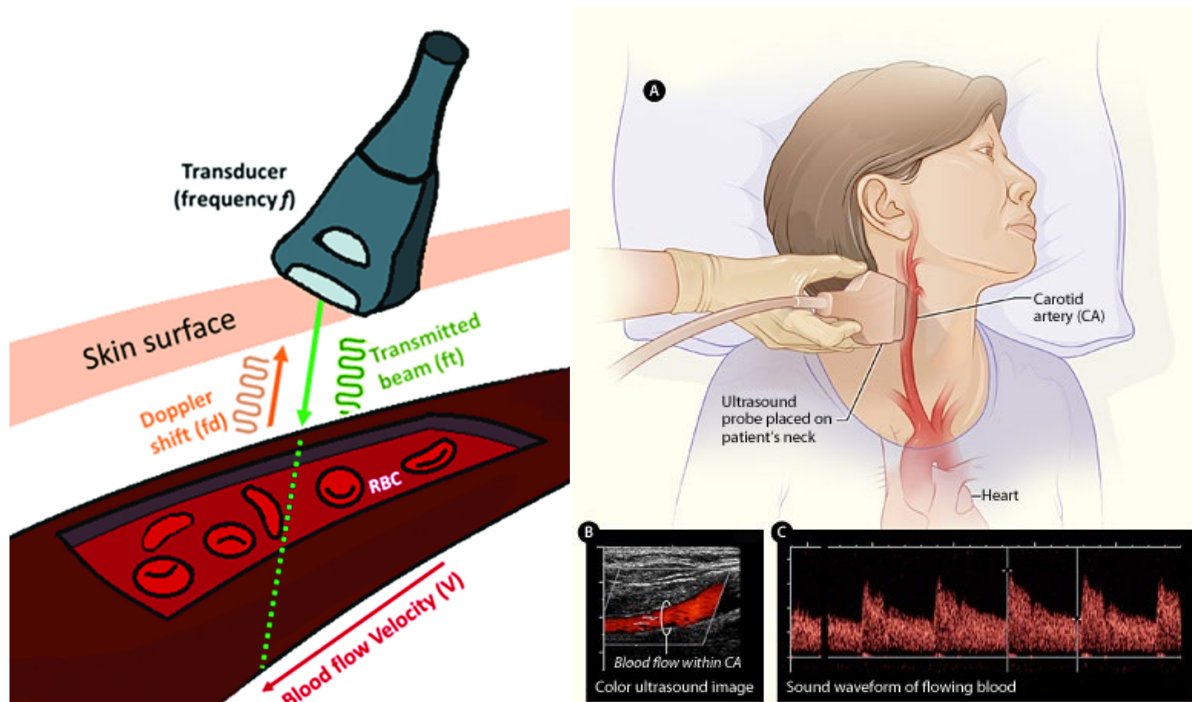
Ultrasound transducer utilizing the Doppler shift from moving red blood cells to measure blood flow velocity (Baratchi et al., 2019). The differences in the echoes from different tissue boundaries are used to produce images of the blood vessels. Applied on a patient, this allows for imaging and blood flow measurement of the carotid artery (NHLBI, 2013).
